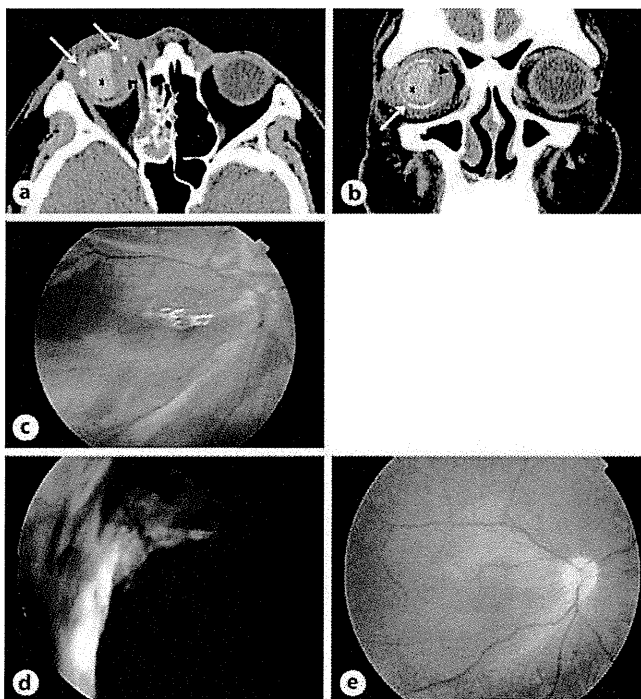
Computed tomography (CT) and fundus photograph after the second surgery. a, b Transversely (a) and coronally (b) sectioned CT images taken 3 days after the second surgery showing that a clot (arrowhead) has been reduced. Arrows indicate encircling band and asterisk indicates silicone oil (S.O.). c Fundus photograph of the right eye taken 15 days after the second surgery showing attached retina under S.O. tamponade and subretinal hemorrhage. Best-corrected visual acuity (BCVA) was 0.07. d, e Fundus photograph of the right eye taken 7 months after the second surgery showing attached retina without any vitreous substitute. BCVA was 0.8.
